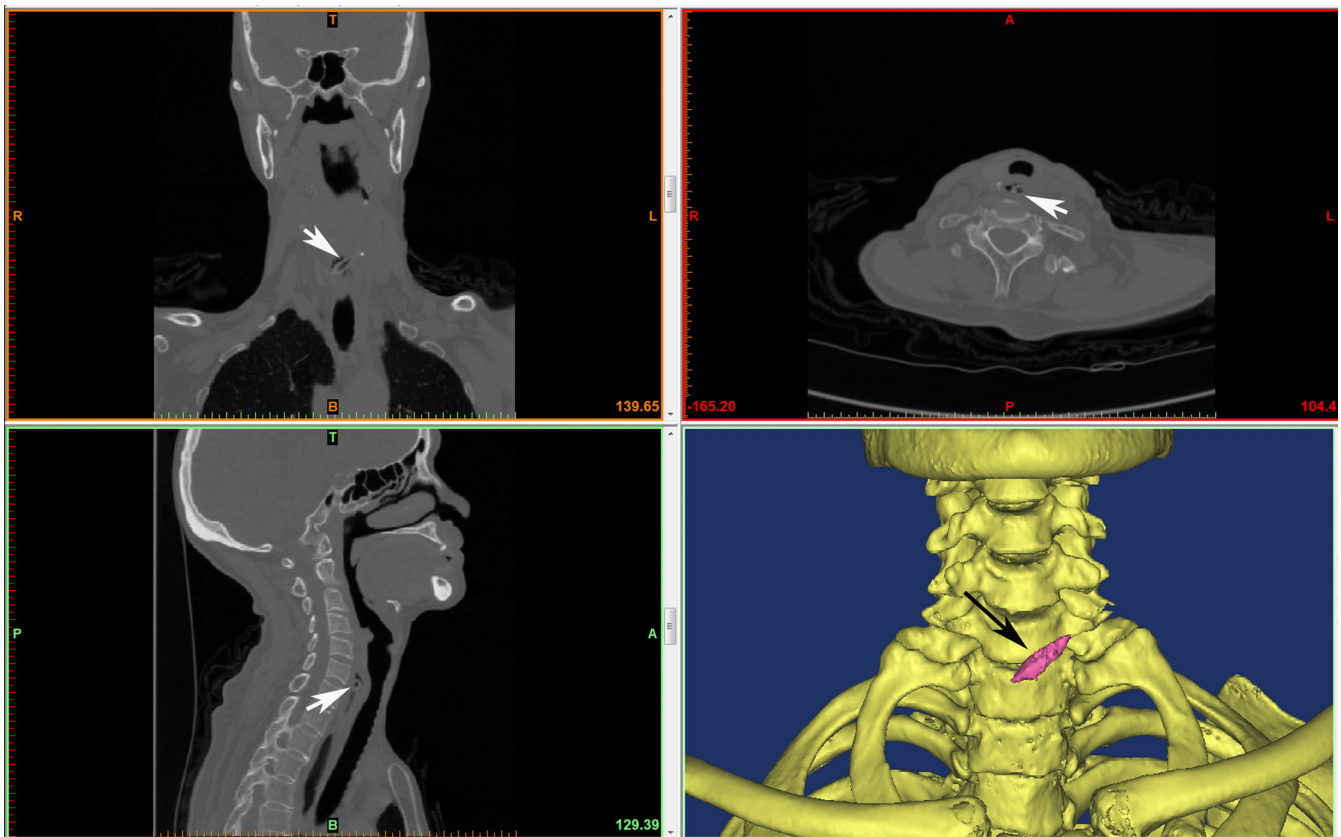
Jujube pits impacted in the inlet of the esophagus shown in CT scanning with image of axial (black arrow), sagittal (black arrow), coronal (black arrow) and 3D reconstruction (white arrow). A, anterior; B, bottom; CT, computed tomography; L, left; P, posterior; R, right; T, top
